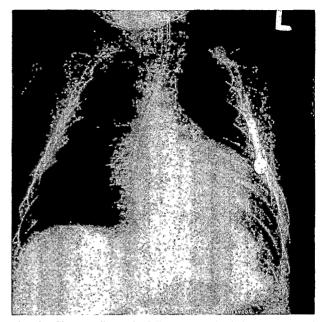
Chest radiograph following tracheal intubation and treatment of cardiac failure.
